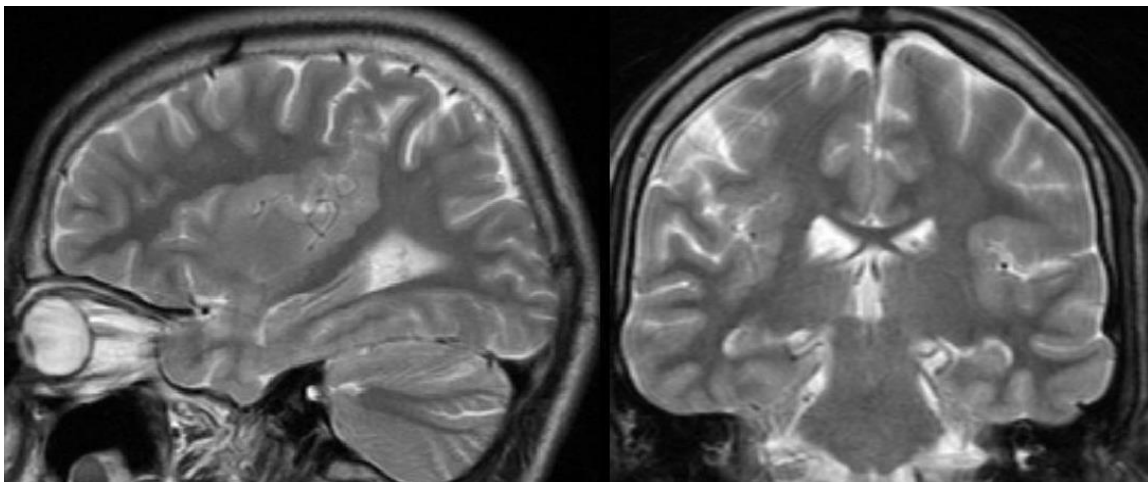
MRI brain T2WI Sagittal (a) and T2WI Coronal (b) images showing the presence of irregular lumpy polymicrogyria along the right perisylvian region.
